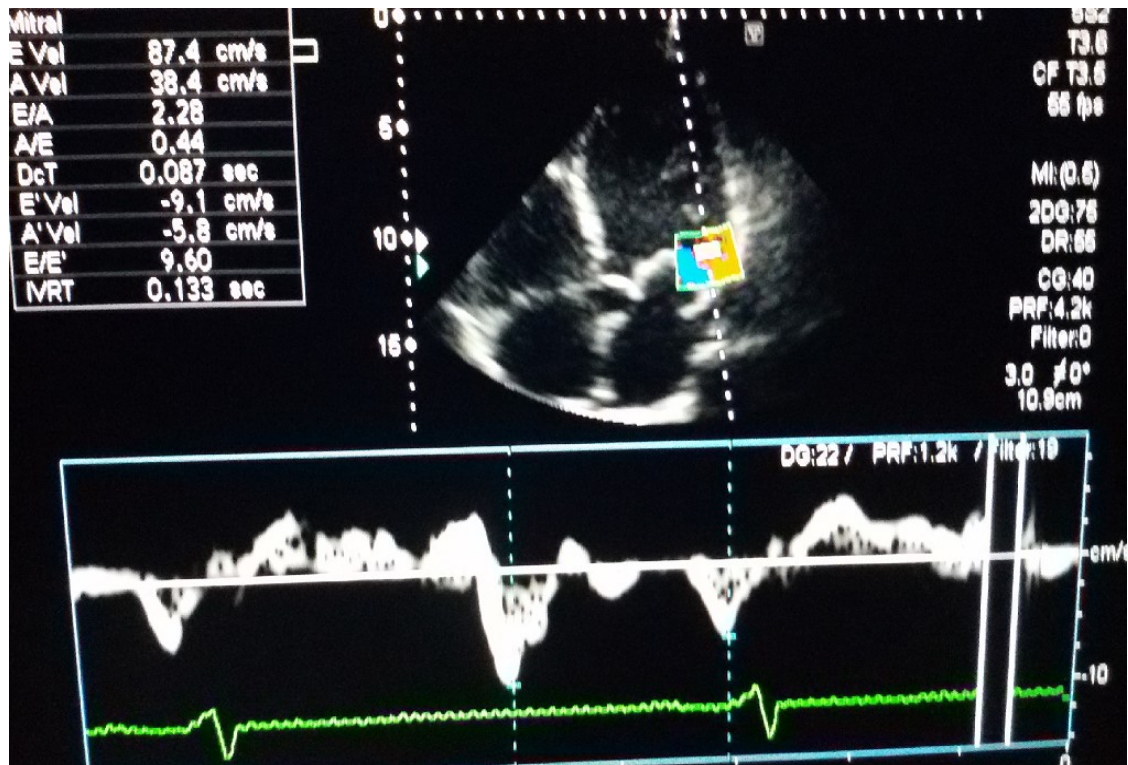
B. Echocardiogram Showing Measurement of Tissue Doppler Imaging (TDI) showing the E' and A' wave
